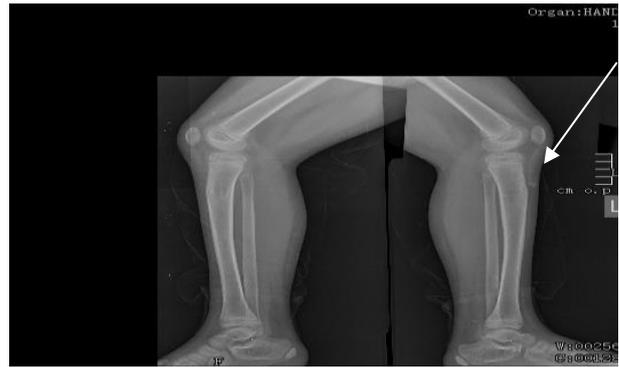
X-ray of legs of calcifications.
